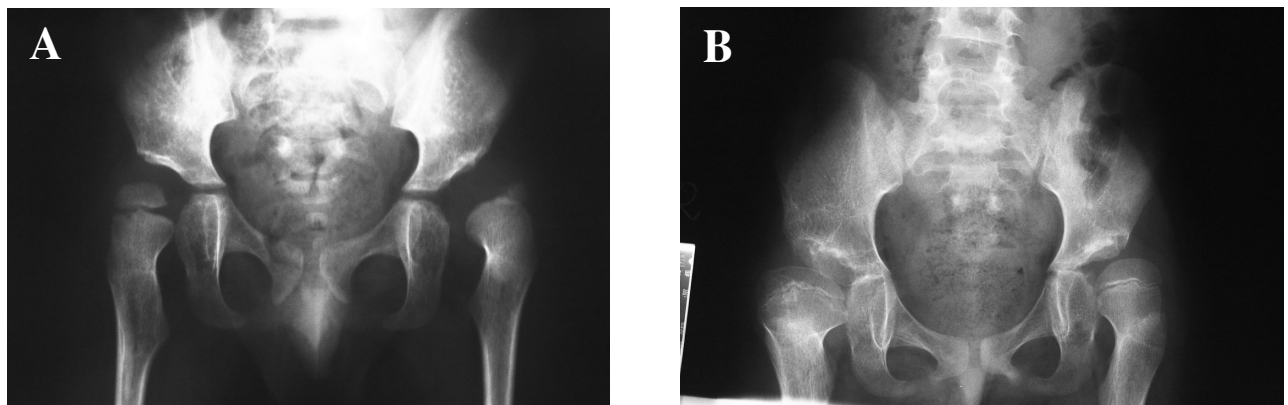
Case 6 (A) Radiograph demonstrating residual dysplasia of the left hip. (B) Follow-up radiograph showing good coverage at 8 years of age.
